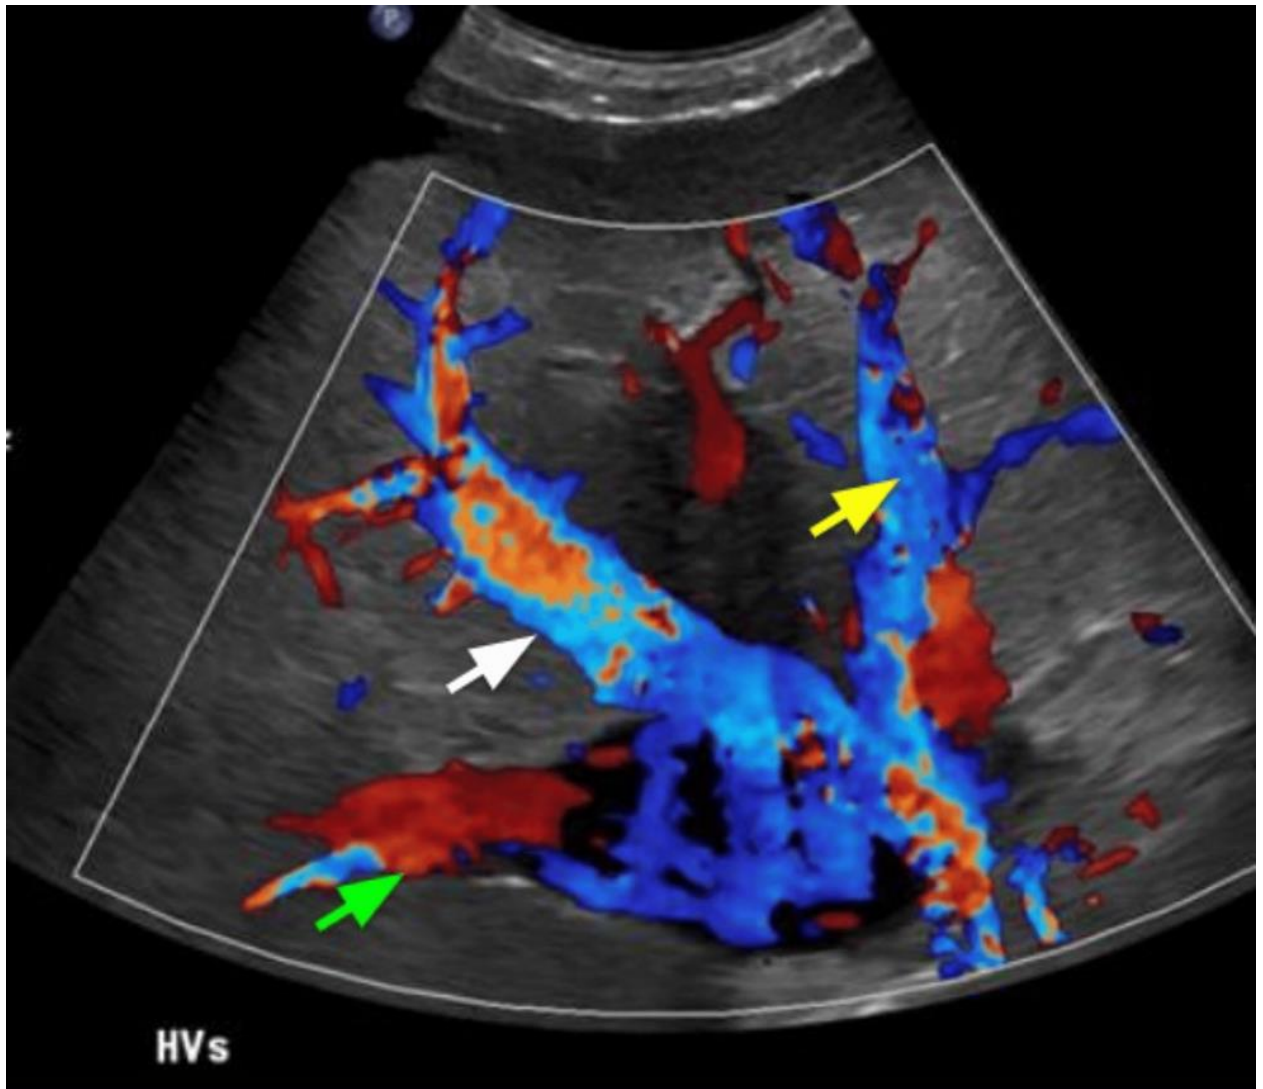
Abdominal Ultrasound with Doppler showing Middle Hepatic Vein (white arrow), Right Hepatic Vein (green arrow), and Left Hepatic Vein (yellow arrow) dilation with appropriate flow direction
